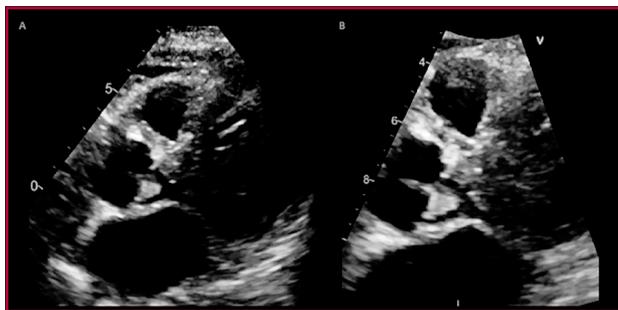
Transthoracic echocardiography. A. Long axis parasternal view showing a 9 x 6 mm sessile nodular image on the ventricular side of the non-coronary cusp of the aortic valve. B. Zoom-in on the nodular image
